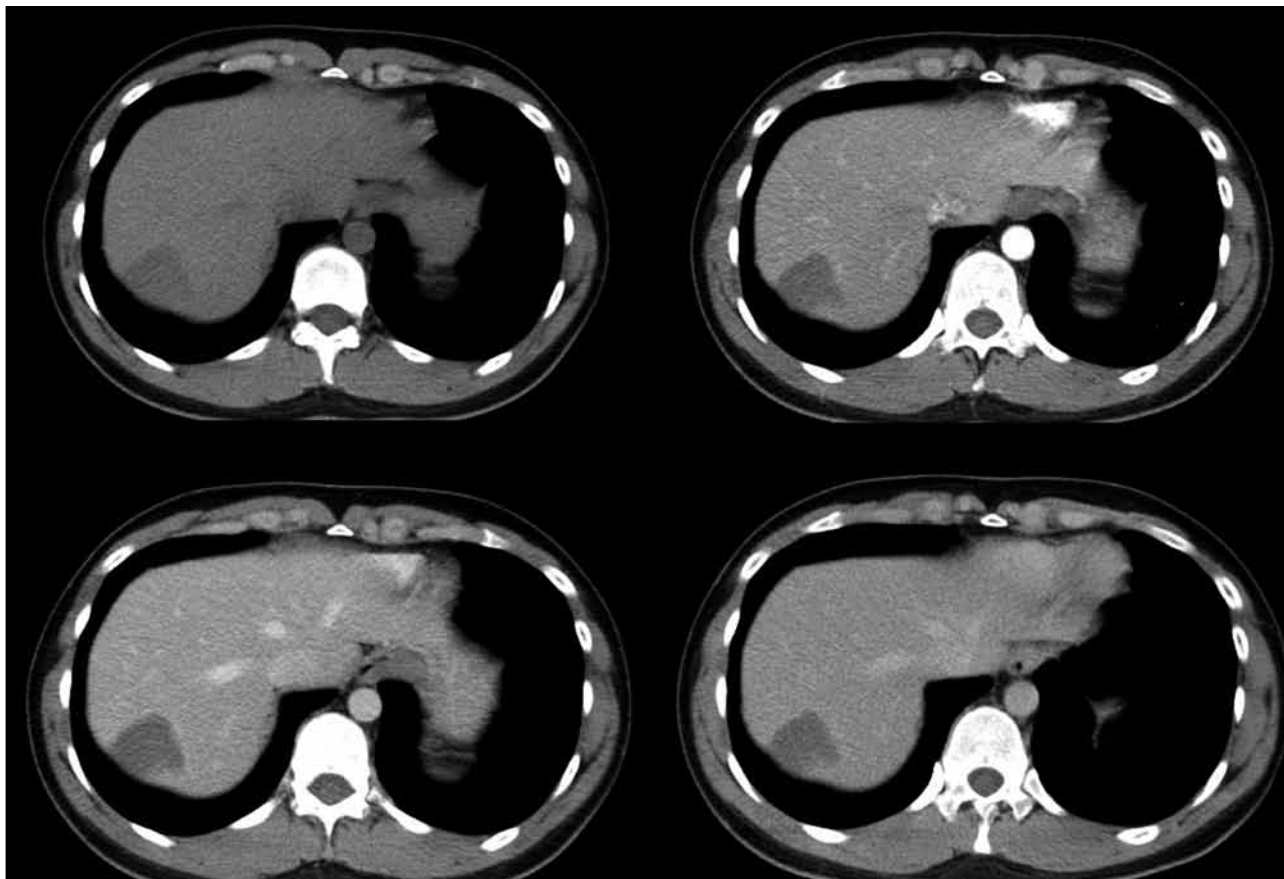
Post-radiofrequency ablation follow-up contrast computed tomography examination shows segment 7 ablation zone without evidence of tumour recurrence.
